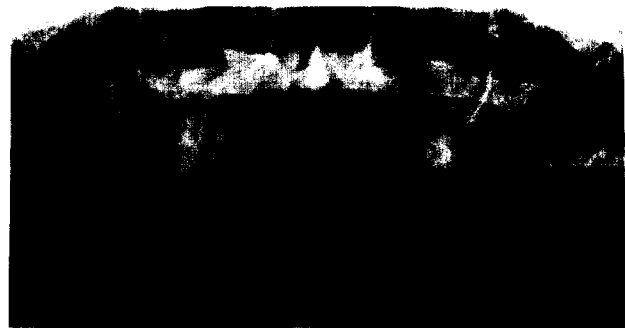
Panoramic radiograph with multilocular radiolucencies.
